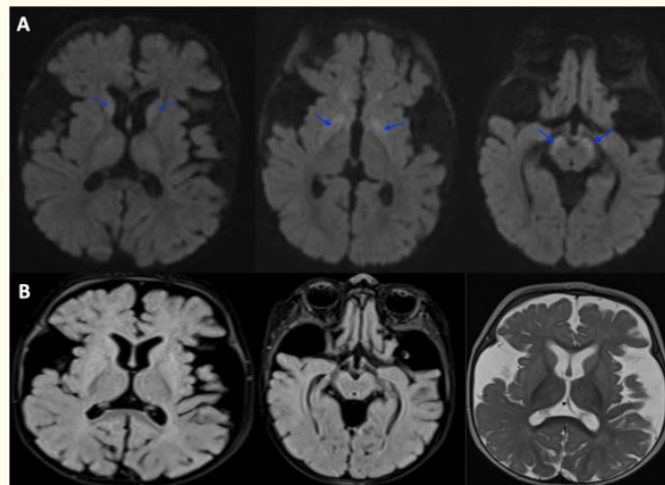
(A) Axial b 1000 DWI image showing a bilateral and symmetric increased signal intensity in the caudate nuclei, lenticular nuclei and cerebral peduncles, without any signal abnormality in axial flair and T2 sequences (B).
